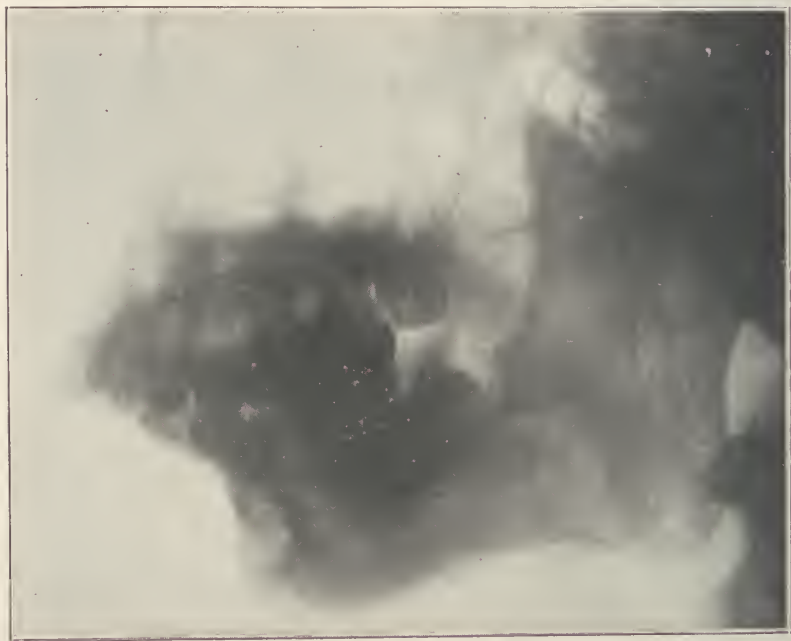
X-ray showing true bony ankylosis of the joint.
